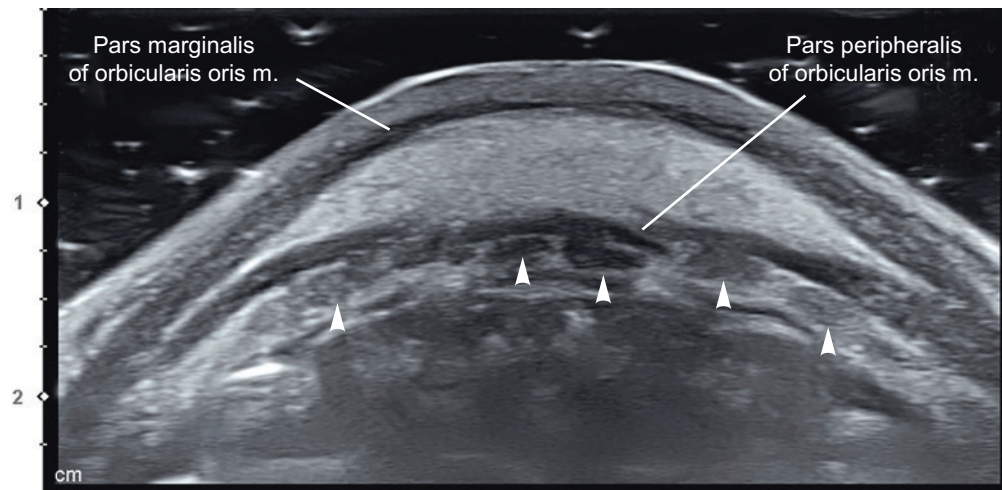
Ultrasonography of intersection point of vermilion border of lower lip and midline (Li1). B mode (transverse view, 15 MHz by linear transducer) (arrowheads: mucous labial glands). (Published with kind permission of © Hee-Jin Kim 2020. All Rights Reserved)
